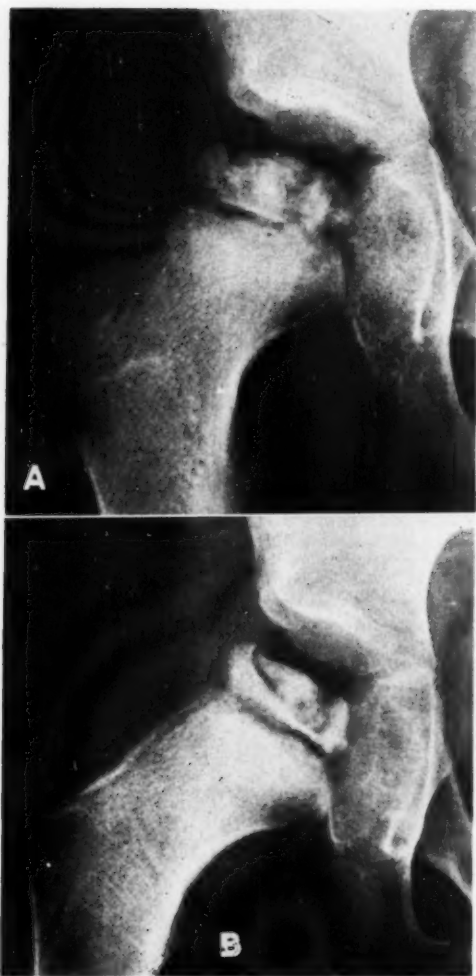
Roentgenograms of the hip of a patient with Perthes' disease demonstrating diffuse mottling of the epiphysis on the routine anteroposterior view (A), with the characteristic lesion ("sequestrum type") clearly seen only on internal rotation (B).
